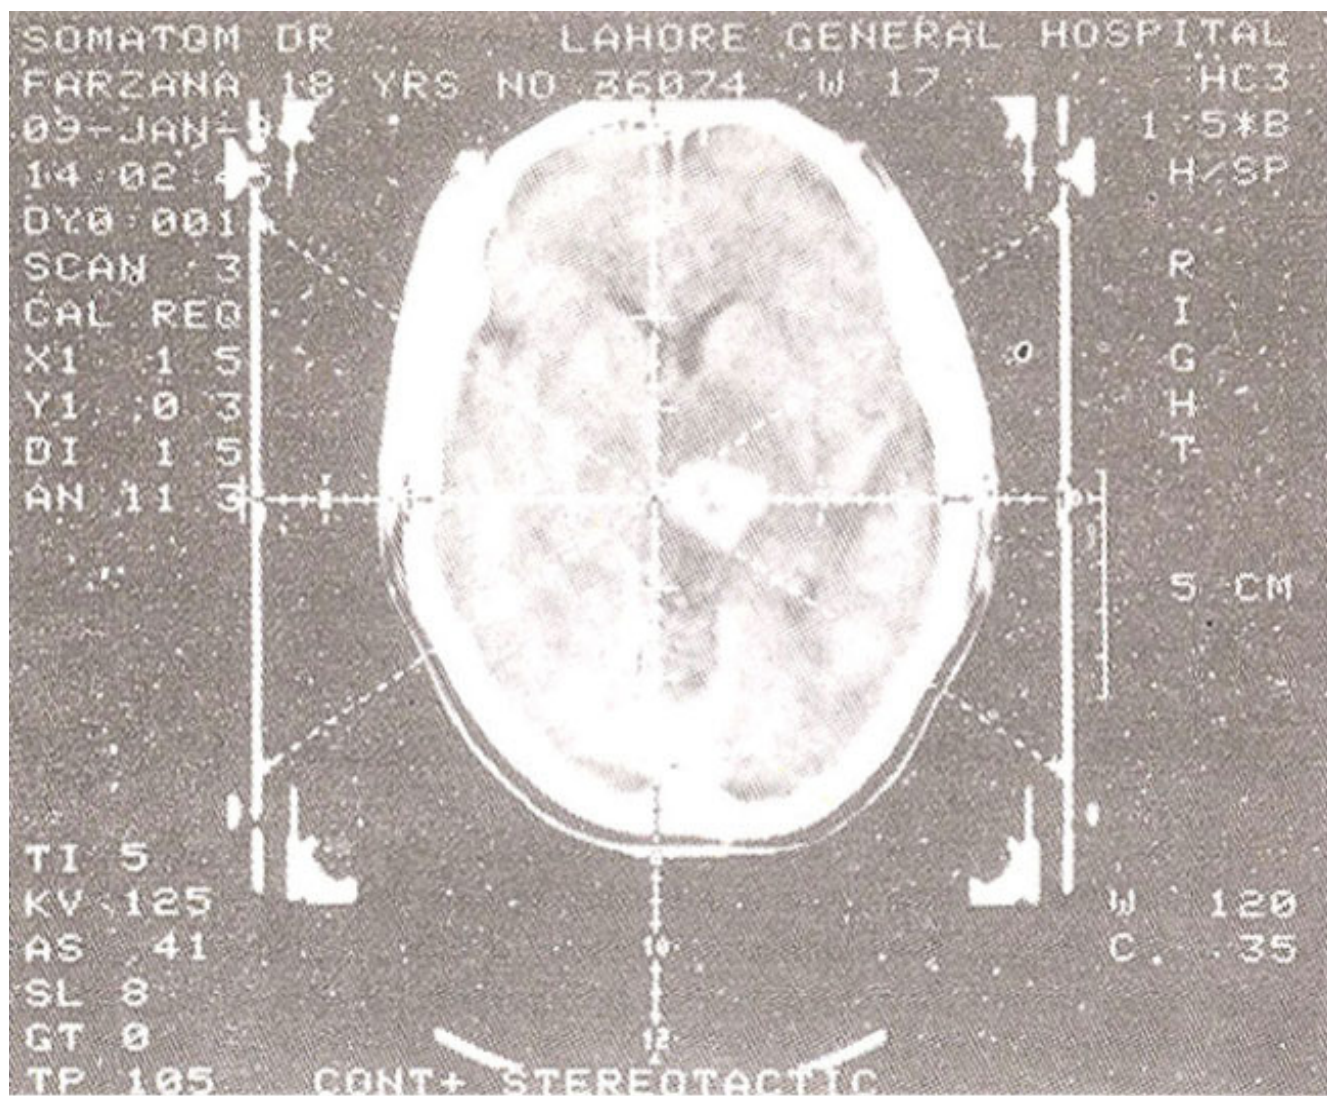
Axial CT scan showing right thalamic glioma with target localization and calculation of coordinates.
